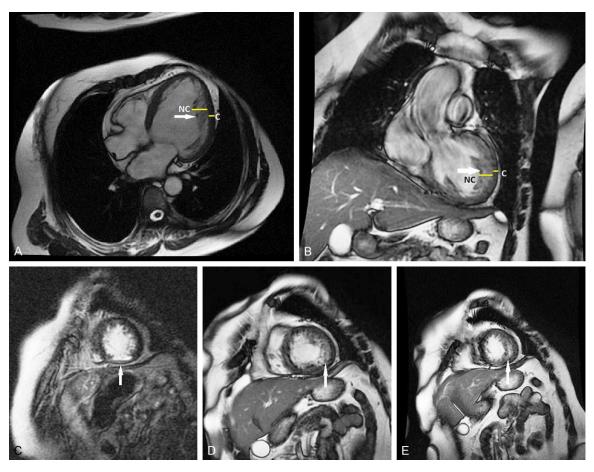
Cardiac MRI: A, B, D and E. The LV wall shows remarkable apex to basolateral trabecularization, and the lateral wall is also involved. The white arrow indicates the non-compacted myocardium. C. The apical subendocardial delayed enhancement suggestive of chronic infarction (white arrow). C, compacted myocardium; NC, non-compacted area.
